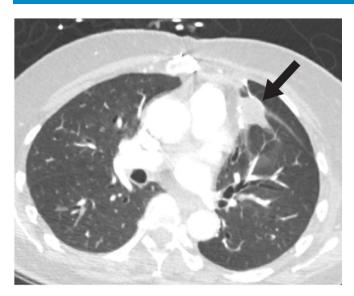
Axial view CT chest with contrast showing thymoma pleural metastases (black arrow).
